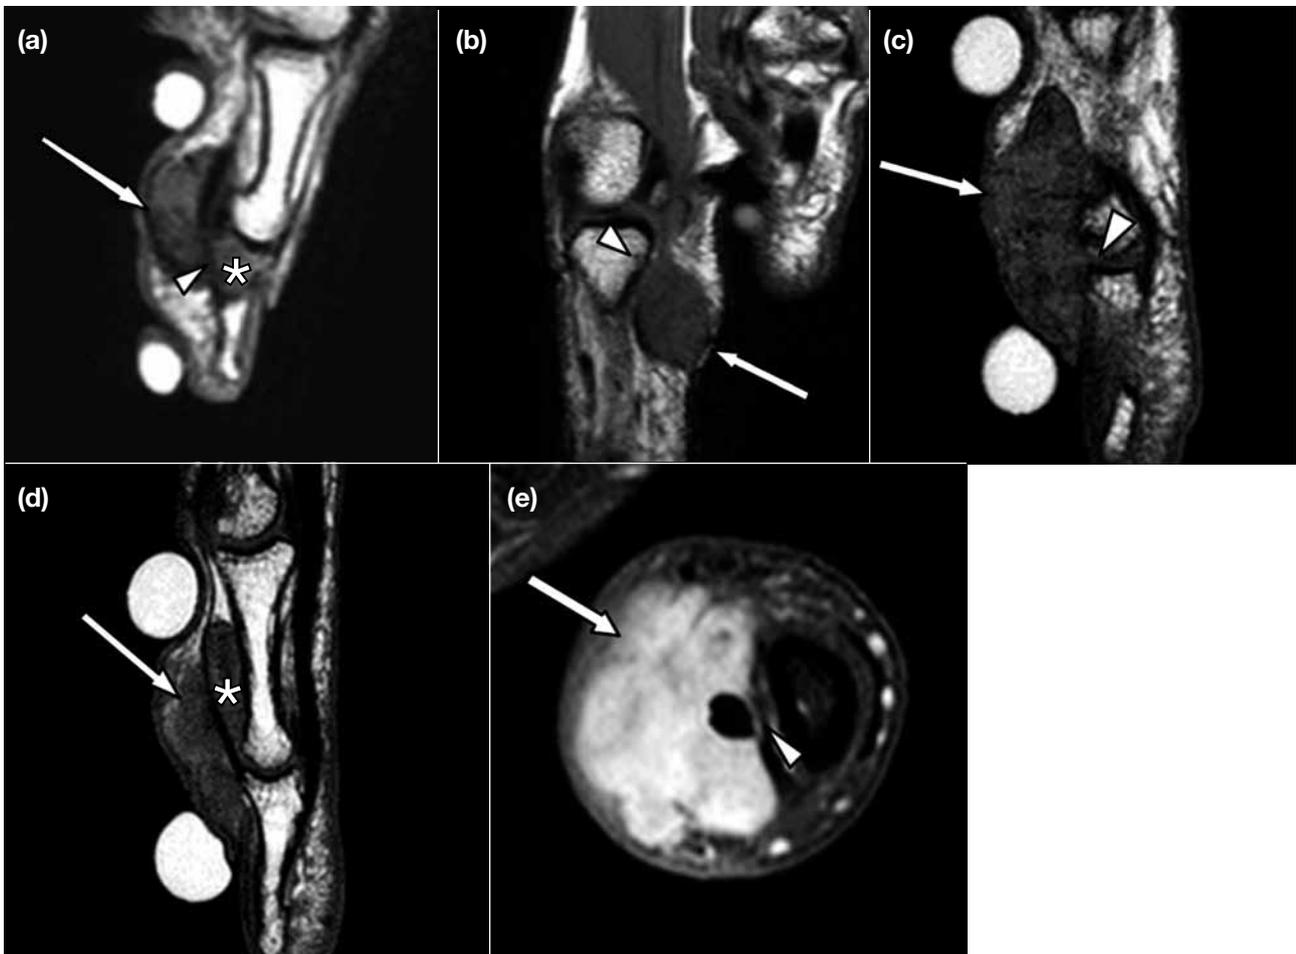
(a) A sagittal turbo spin-echo (TSE) T1-weighted magnetic resonance image (MRI) (TR/TE = 778/20) shows a giant cell tumour of the tendon sheath (arrow) erodes into the volar cortical surface (arrowhead) and extends into the proximal portion of the distal phalangeal bone (asterisk). (b) A sagittal TSE T1-weighted MRI (TR/TE = 504/20) shows a tiny focus of abnormal marrow signal intensity and cortical bone erosion (arrowhead) in the volar aspect of the proximal phalanx of right index finger adjacent to the soft tissue mass (arrow). These findings were not detected by our two reviewers. At surgery, slight bony erosion was found. (c) A sagittal TSE T1-weighted MRI (TR/TE = 598/20) shows a giant cell tumour of the tendon sheath (arrow) invading into the joint (arrowhead). (d) A sagittal TSE T1-weighted MRI (TR/TE = 598/20) shows a giant cell tumour of the tendon sheath (arrow) invading the space between the extensor tendon and the phalanx (asterisk), which suggests invasion of the tenosynovial space. (e) An axial TSE T1-weighted MRI with fat suppression after gadolinium contrast (TR/TE = 556/20) shows an avidly enhancing soft tissue mass (arrow) with apparent soft tissue in the space between the flexor tendon and the phalanx (arrowhead). However, no invasion of the tenosynovial space was found in the surgery.
